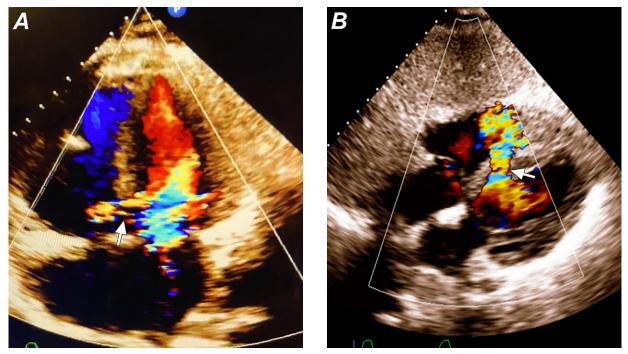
Transthoracic echocardiograms (color-flow Doppler mode) in A) apical 4-chamber and B) subcostal views show left-to-right shunting through a ventricular septal rupture (arrows).
